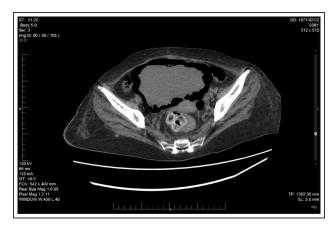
Abdominal CT scan shows gas within the bladder wall and lumen.
